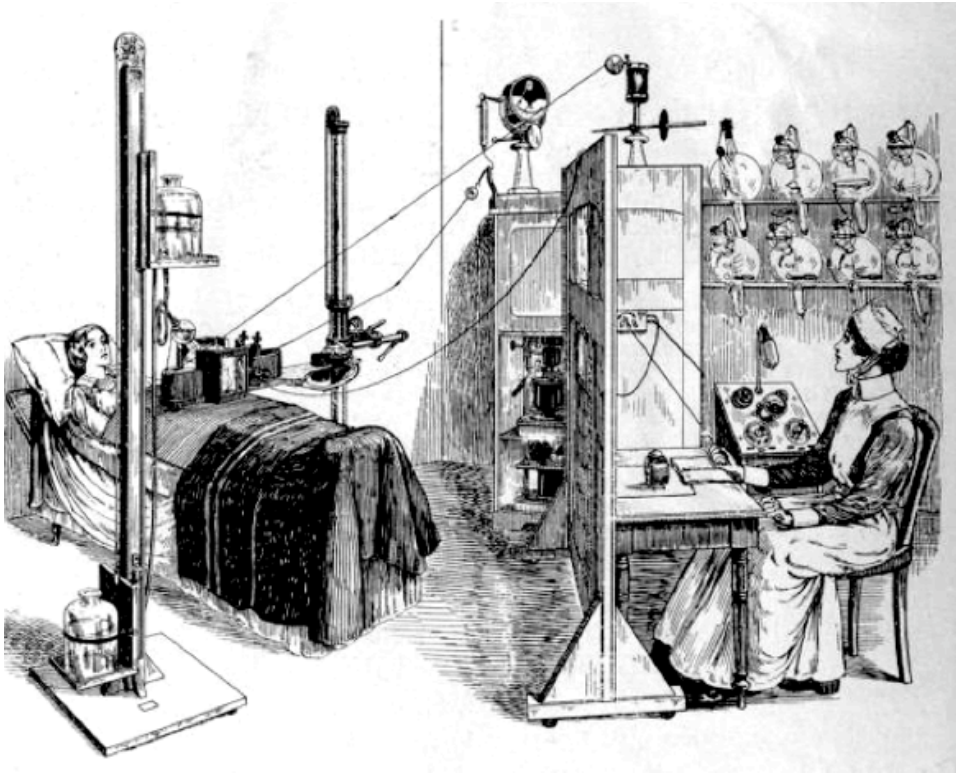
X-Ray treatment for uterine fibroids c. 1918³⁵⁰
